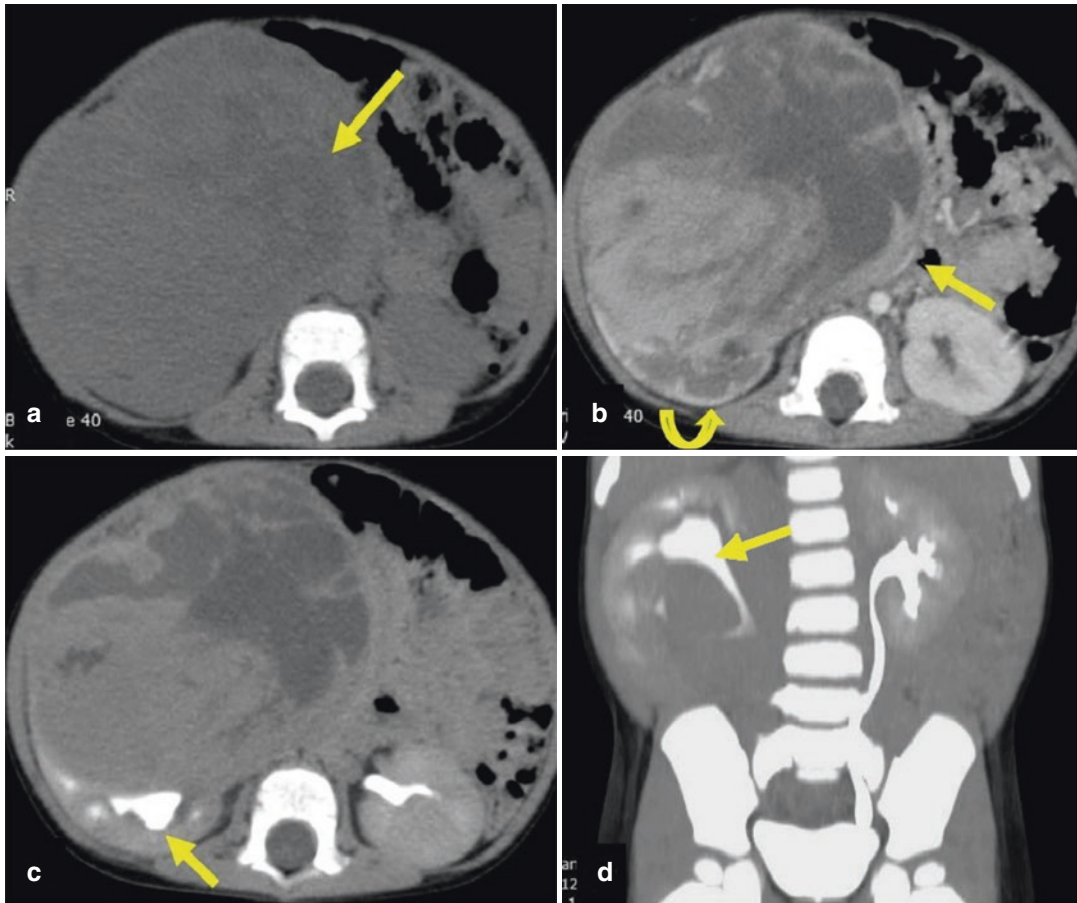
CT scan of a 1.5-year-old child clinically suspected of WT. (a) NCCT axial image shows a large solid mass in the right renal fossa with necrotic areas (arrow), with no calcification or hemorrhage. (b) CECT axial image reveals a large, heterogeneously enhancing mass arising from lower pole of the right kidney replacing most of the kidney and causing leftward displacement of IVC
